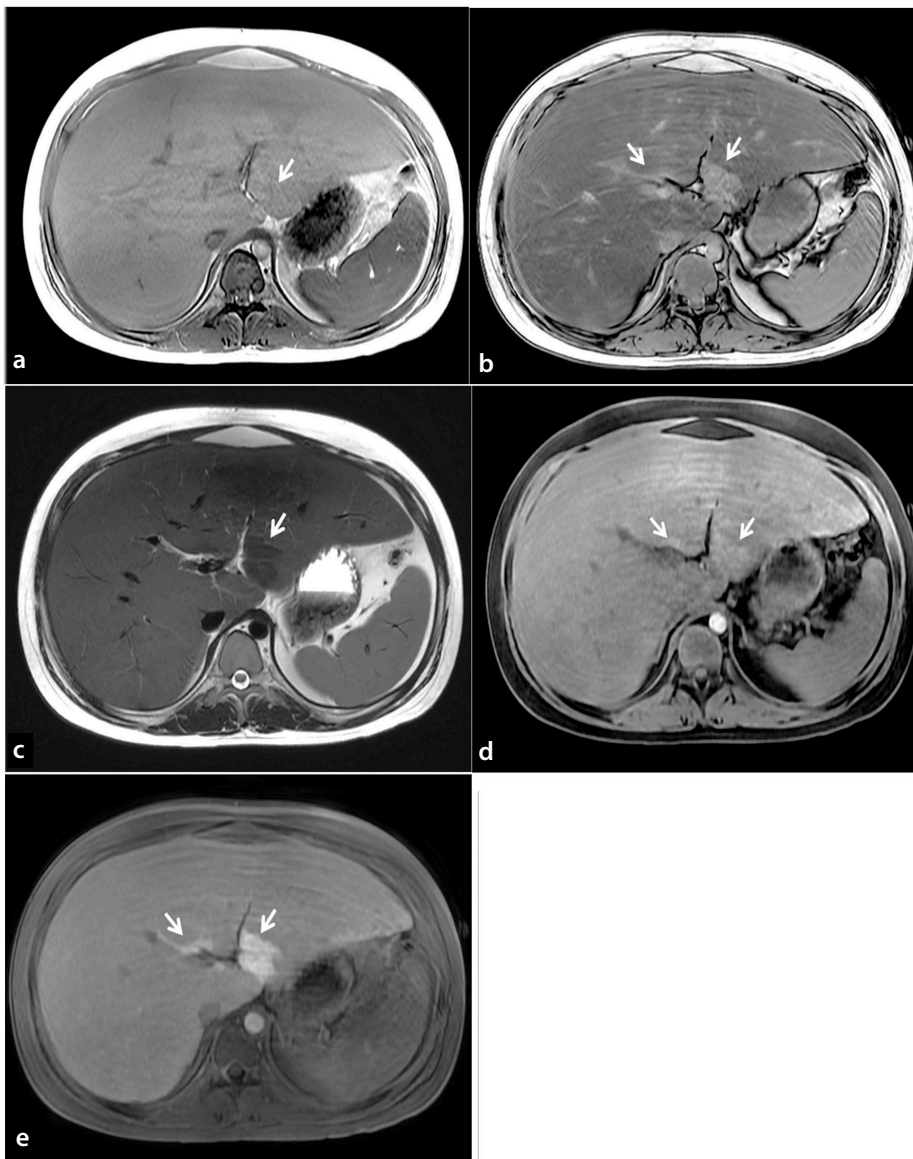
An 18-year-old boy with type 1 glycogen storage disease underwent liver magnetic resonance imaging using a hepatobiliary contrast agent. (a, b) In-phase (a) and opposed-phase (b) images indicating liver steatosis with decreased signal intensity on the opposed-phase image and fat spared areas in segments 2 and 4 (arrows). (c, d) Axial T2-weighted image indicating hypointensity (arrow), and precontrast fat-suppressed T1-weighted image displaying hyperintensity (arrow) at the focal fat spared area. (e) Hyperintensity at the focal fat spared area (arrows) on the hepatobiliary phase image 20 min after gadoxetate disodium injection.
